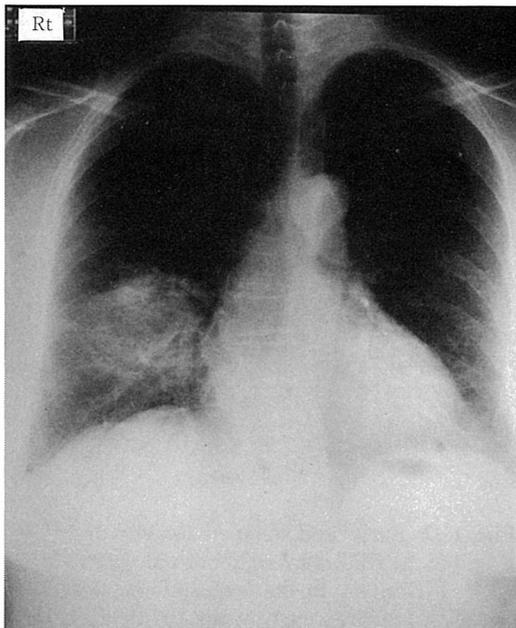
Chest radiography showed ill defined lobar consolidation in the right middle lobe.
